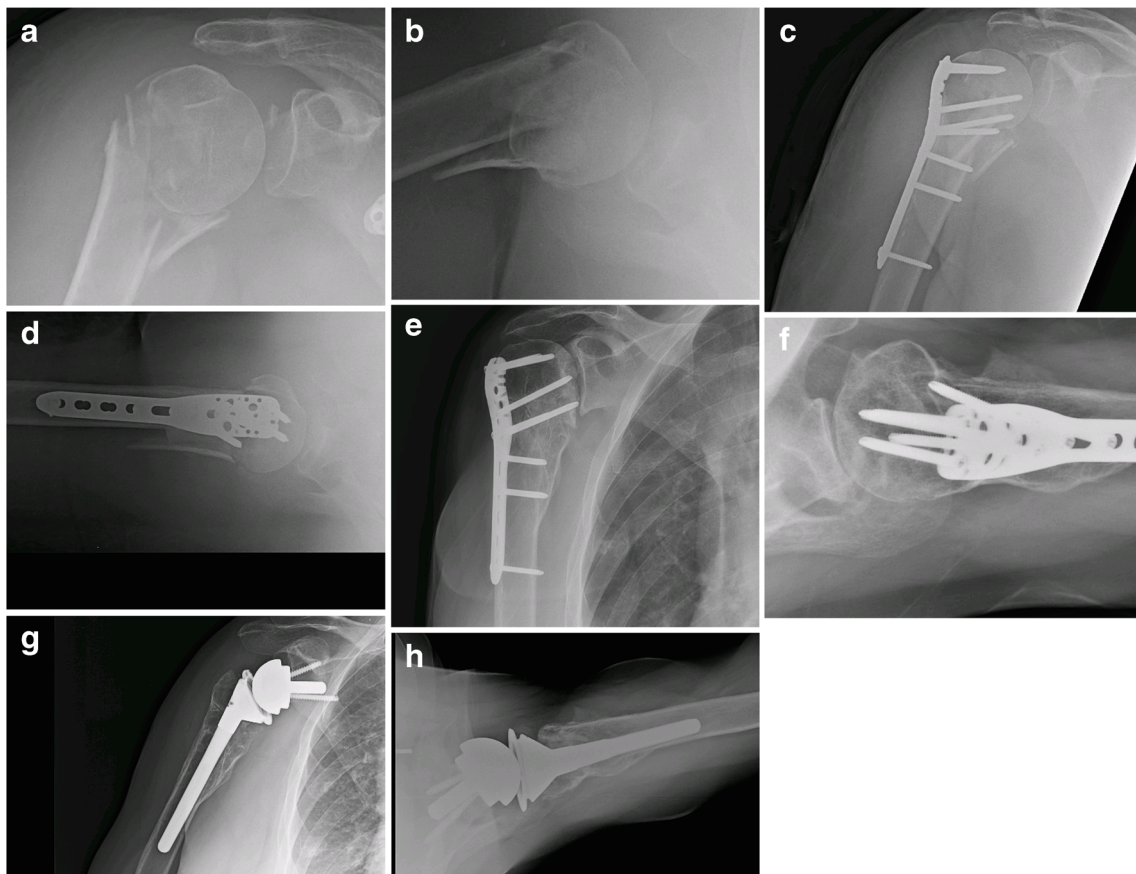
This 62-year-old female sustained a 4-part proximal humerus fracture (Grashey anteroposterior and axillary radiographs shown in a and b), underwent open reduction and internal fixation with fibular strut allografting (c, d). Two-and-a-half years later, the patient presented with increasing pain. On examination the patient was found to have 80° active forward elevation and weakness in all planes of the rotator cuff.
